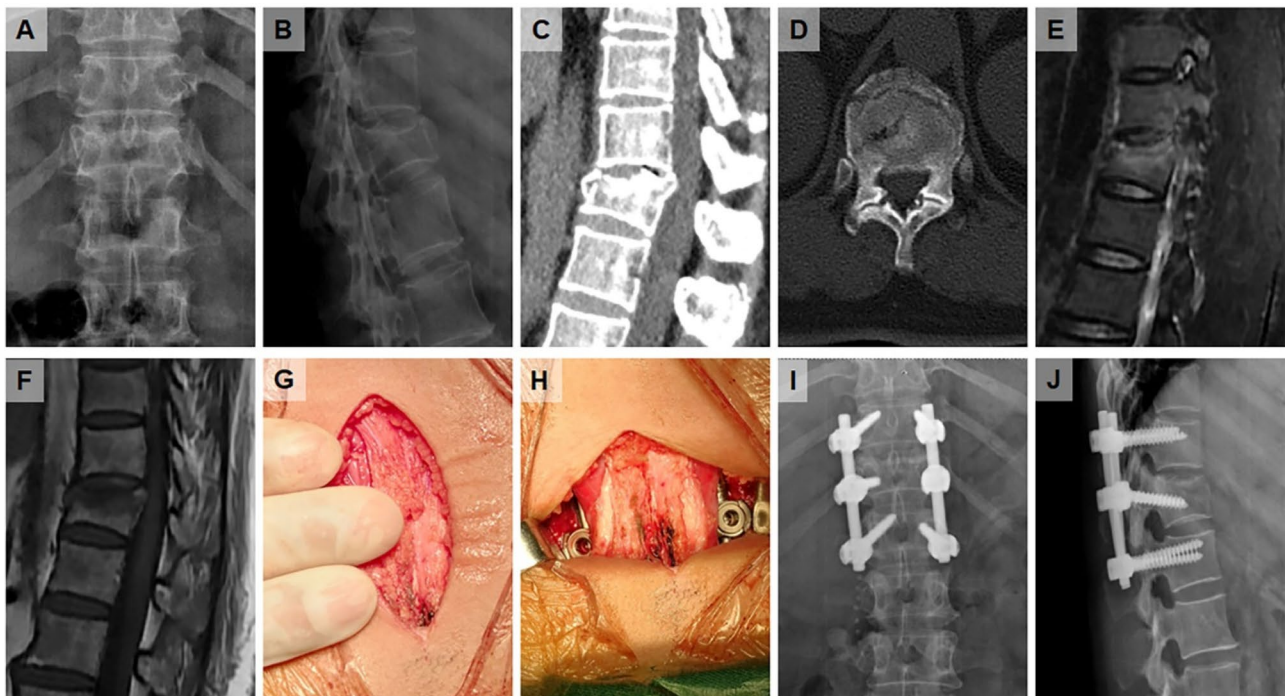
Case presentation of a 50-year-old male patient who suffered a T11 fracture due to a fall from height and underwent surgery via the modified Wiltse approach. (A, B) Preoperative X-ray radiograph of the thoracic spine; (C, D) Preoperative sagittal CT scan of the fractured thoracic vertebra; (E, F) Preoperative MRI scan confirming the thoracic vertebral fracture and excluding nerve injury; (G, H) Intraoperative anatomy of the modified Wiltse approach; (I, J) Postoperative X-ray radiograph of the thoracic spine
